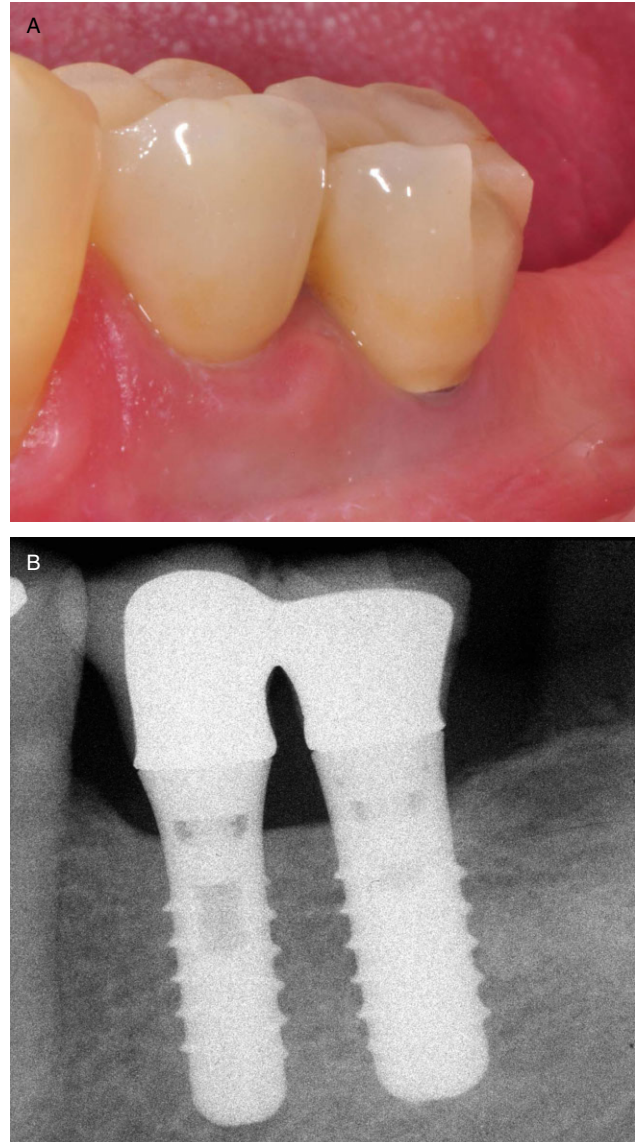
A and B, Clinical picture and radiograph of the present study showing ceramic fracture.
